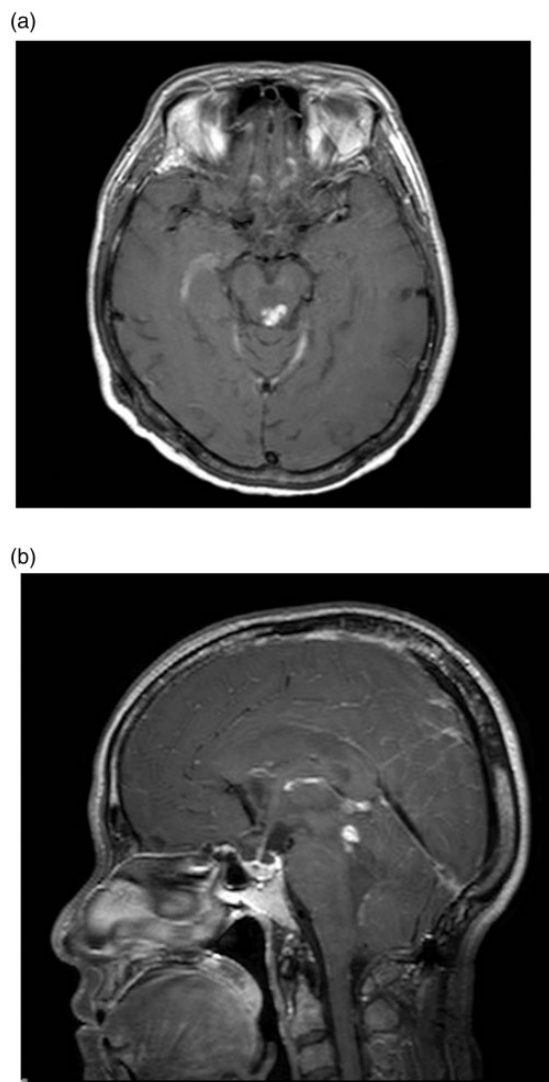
Two-year postoperative MRI shows ~1 cm residual intraventricular tumor tissue at lower part of the cerebral aqueduct.
